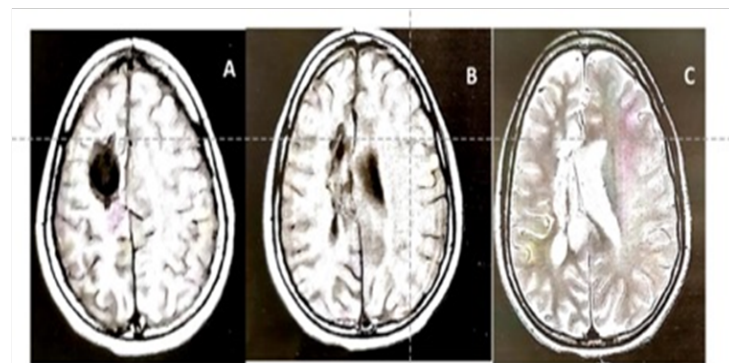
Post hemispherotomy control MRI showing the right cortical parietal and deep hemispherotomy sequel with moderate right unihemispheric atrophy: A and B sequence T1, C sequence T2.
